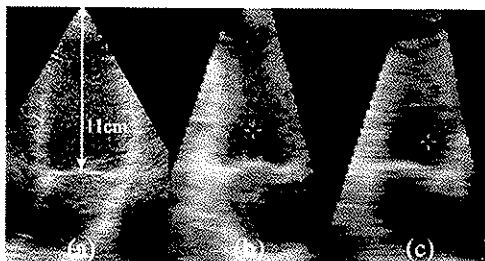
(a) Original apical four-chamber 2-D slice. The mitral valve is located at 11 cm depth. (b) Slice in the elevation direction with high sampling density. (c) Same slice as (b), but with lower resolution.
